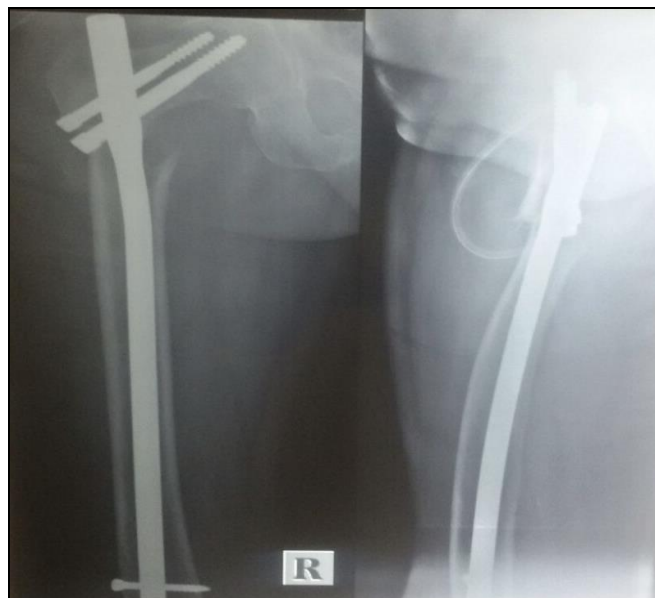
Post-operative radiograph of case 1 with Long PFN in situ
